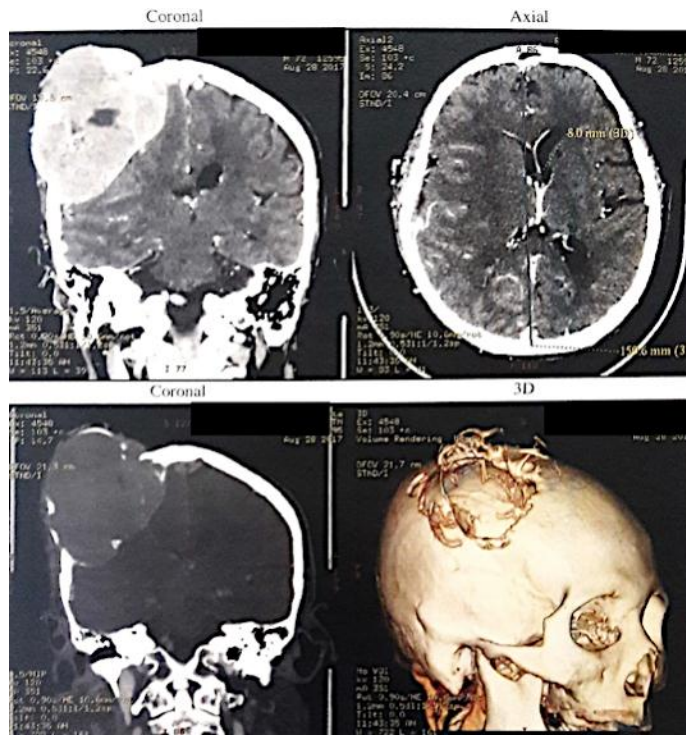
Head CT scan with contrast and 3D reconstruction.
